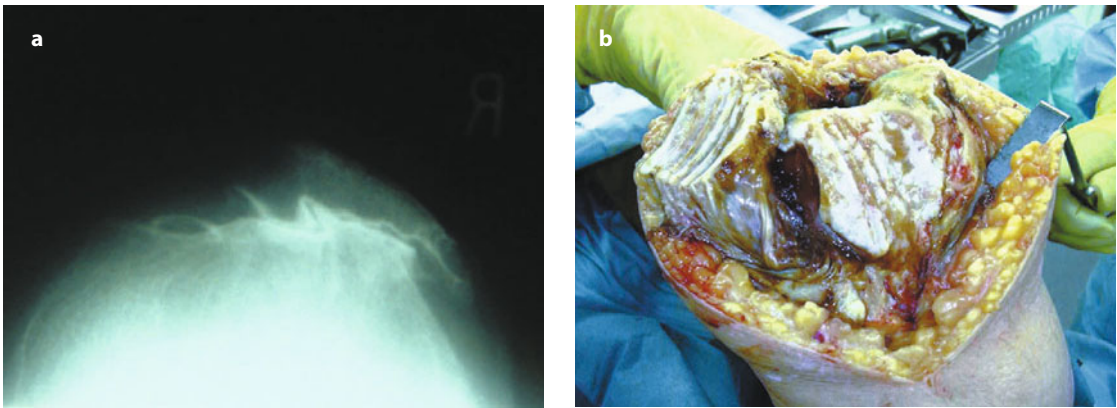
a, b Skyline X-ray and operative picture of an elderly woman with gross ridging of the patellofemoral joint. The tibiofemoral joint was well preserved
